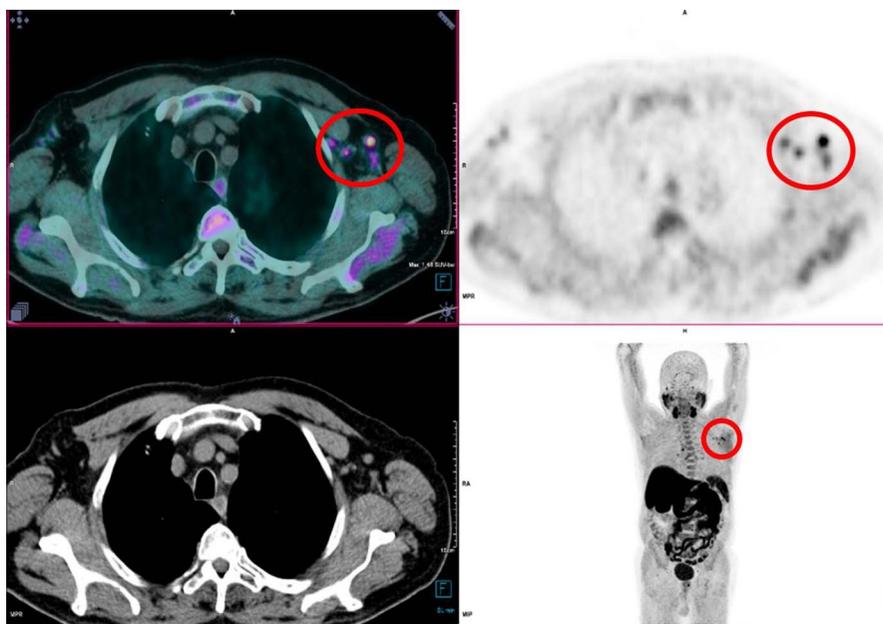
An 81-year-old man underwent an ^{18}F -fluorocholine PET/CT for rising PSA after PCa radiotherapy. Multiple left axillary LNs (red circle) with higher uptakes than the mediastinum were observed. The man received the first and second doses of the BNT162b2mRNA (Pfizer-BioNTech) vaccine, respectively, 24 and 3 days before undergoing this PET/CT.
